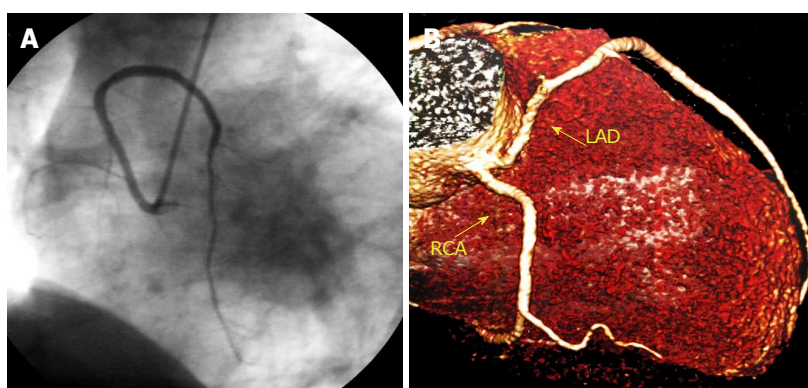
Ectopic left anterior descending artery originating from the right sinus of Valsalva. A: Left anterior oblique view with cranial angulation of the left anterior descending artery (LAD) originating from the right Valsalva sinus in coronary angiogram; B: Reconstructed image from computed tomography coronary angiogram showing both LAD and right coronary artery arising from the right sinus of Valsalva. From the authors' personal dataset. LAD: Left anterior descending; RCA: Right coronary artery.
